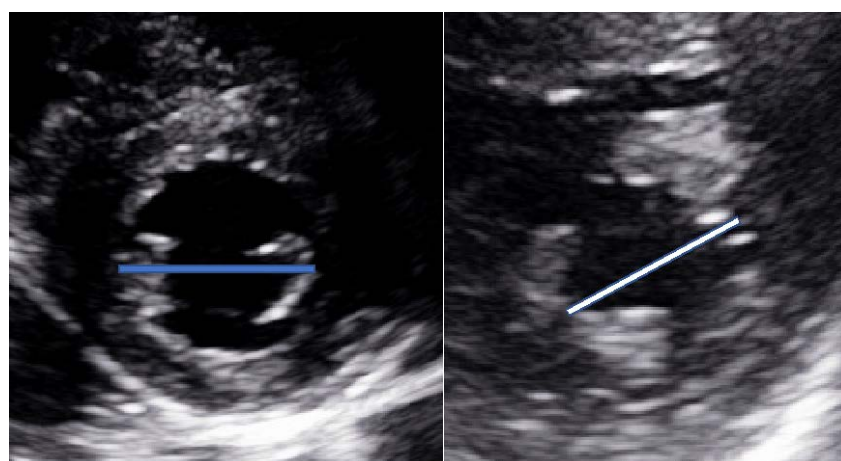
Echocardiography picture showing ascended antero-lateral papillar muscle (white line) compare to the normal position (Blue line).
